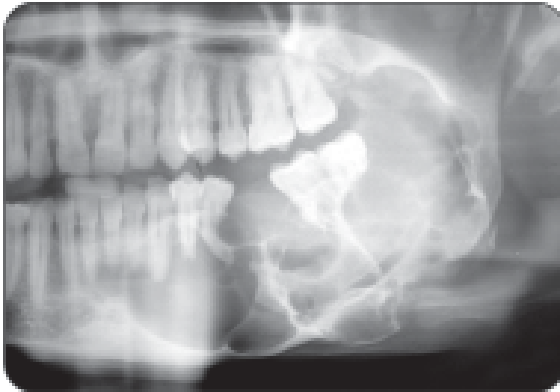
Radiograph of ameloblastoma-I
